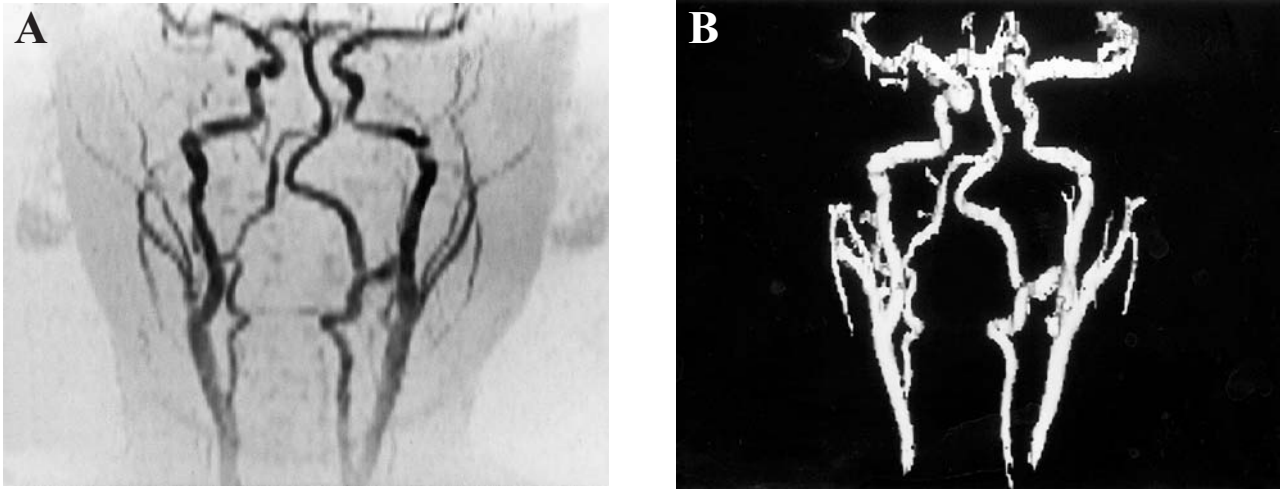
Medial deviation of the left internal carotid artery in patient no. 3. Tortuosity and kinking of the vertebrobasilar arteries are shown in this MRA study (A) compared with the same patient's CTA (B), showing marked deviation of the internal carotid artery at the C2 level but no presentation of the vertebrobasilar system.
